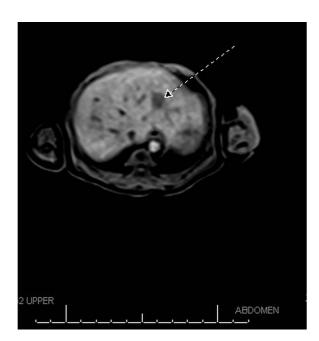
Post-surgery MRI showing intra-hepatic lesion (arrow).
